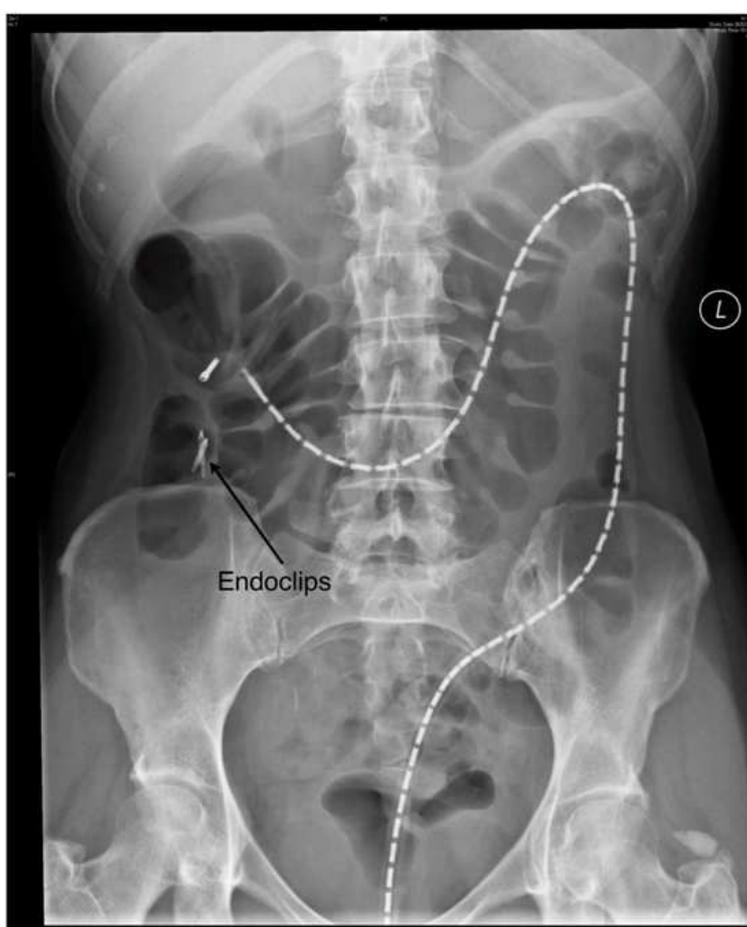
Plain abdominal radiograph showing in situ placement of a high-resolution manometry catheter.
